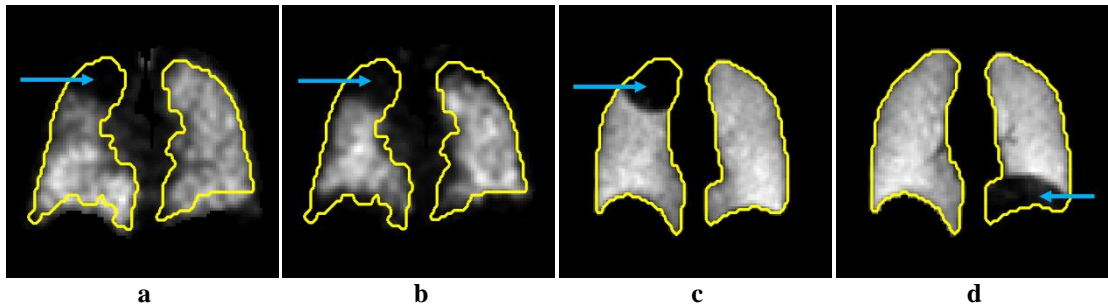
Abnormal SPECT V and Q images. The yellow contours present the boundaries of lungs. The photopenic region (pointed by blue arrow) indicates the location of defects.
